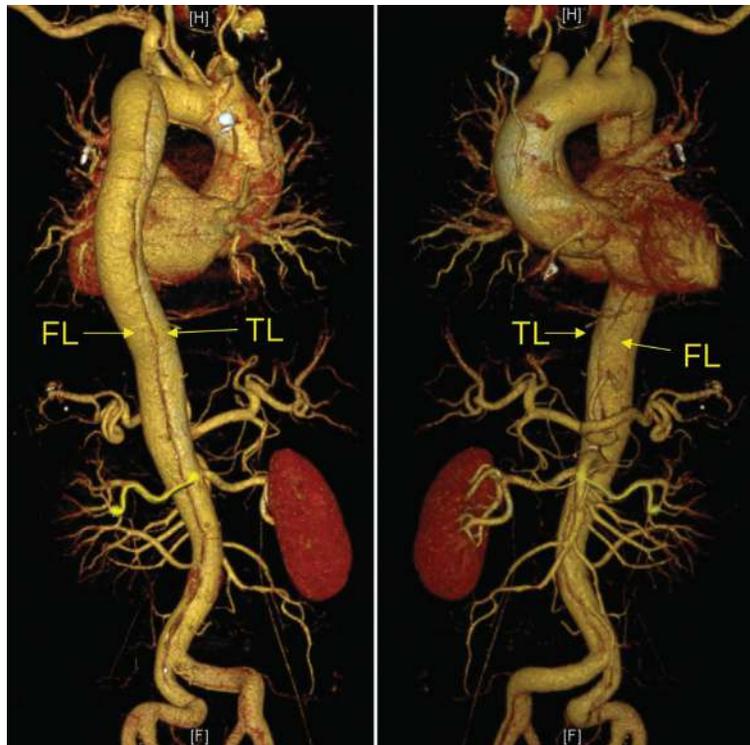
Three-dimensional computed tomographic angiogram of type A aortic dissection. (A) anteroposterior view; (B), posteroanterior view. *FL*, False lumen; *TL*, true lumen.
